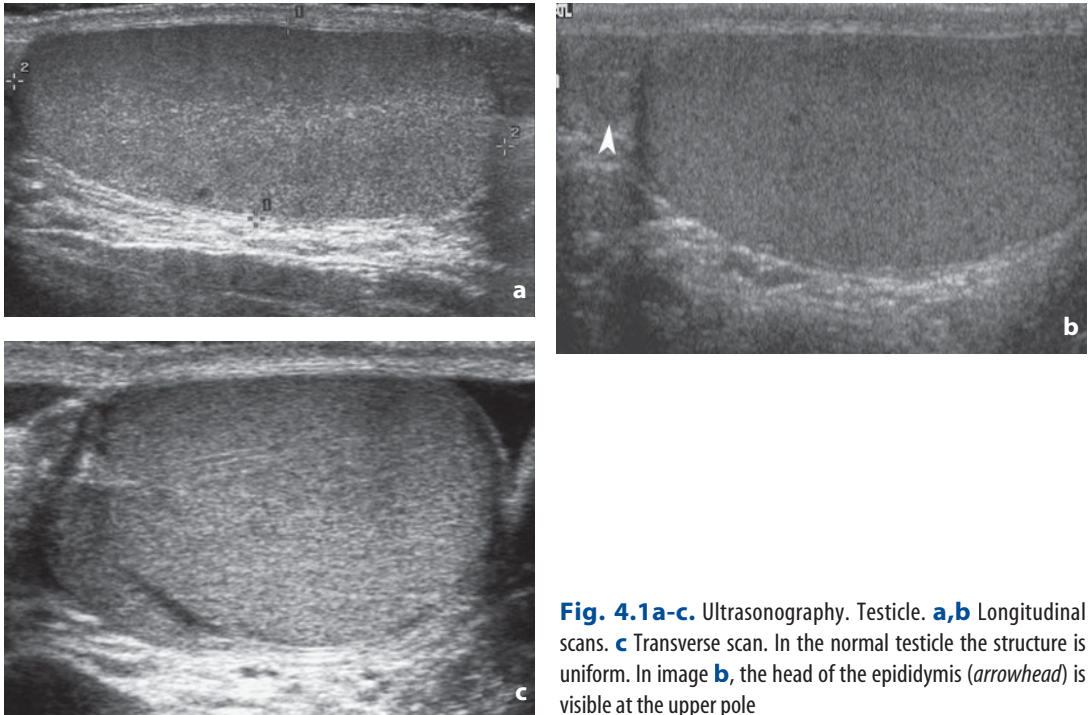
Ultrasonography. Testicle. a,b Longitudinal scans. c Transverse scan. In the normal testicle the structure is uniform. In image b, the head of the epididymis (*arrowhead*) is visible at the upper pole
